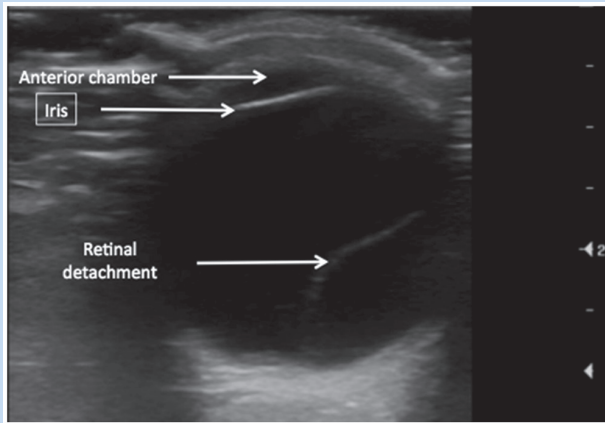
Diagnostic ultrasound image revealing a retinal detachment. The detached retina is seen as a linear, hyperechoic structure within the anechoic vitreous body and is tethered to the globe. Top of image, superficial; bottom of image, deep; left side of image, medial; right side of image, lateral.
